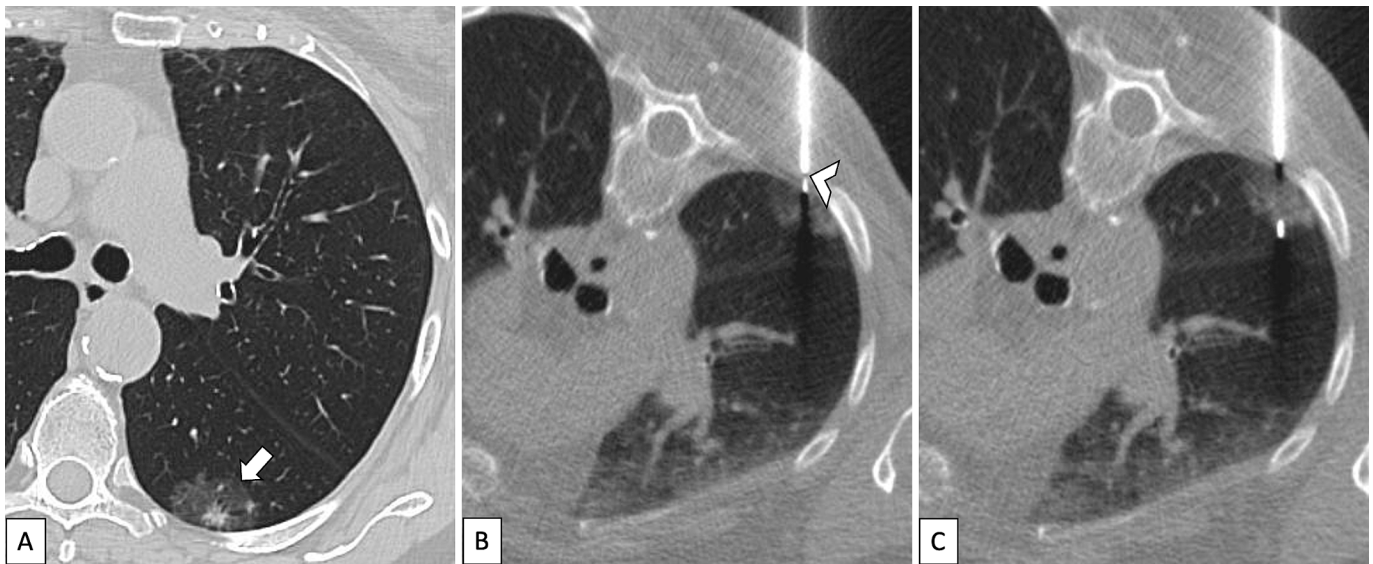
A-C. CT-guided transthoracic core needle biopsy of a subpleural subsolid nodule located in the left lower lobe (arrow). B. The introducer tip (arrowhead) was positioned near the pleural surface. C. Then, the cutting needle was directly advanced through the pleura into the target, avoiding the need for pull-back repositioning and minimizing the risk of hemorrhage obscuring the target due to coaxial needle introduction into the lung parenchyma. The final diagnosis was lung adenocarcinoma with lepidic growth.
